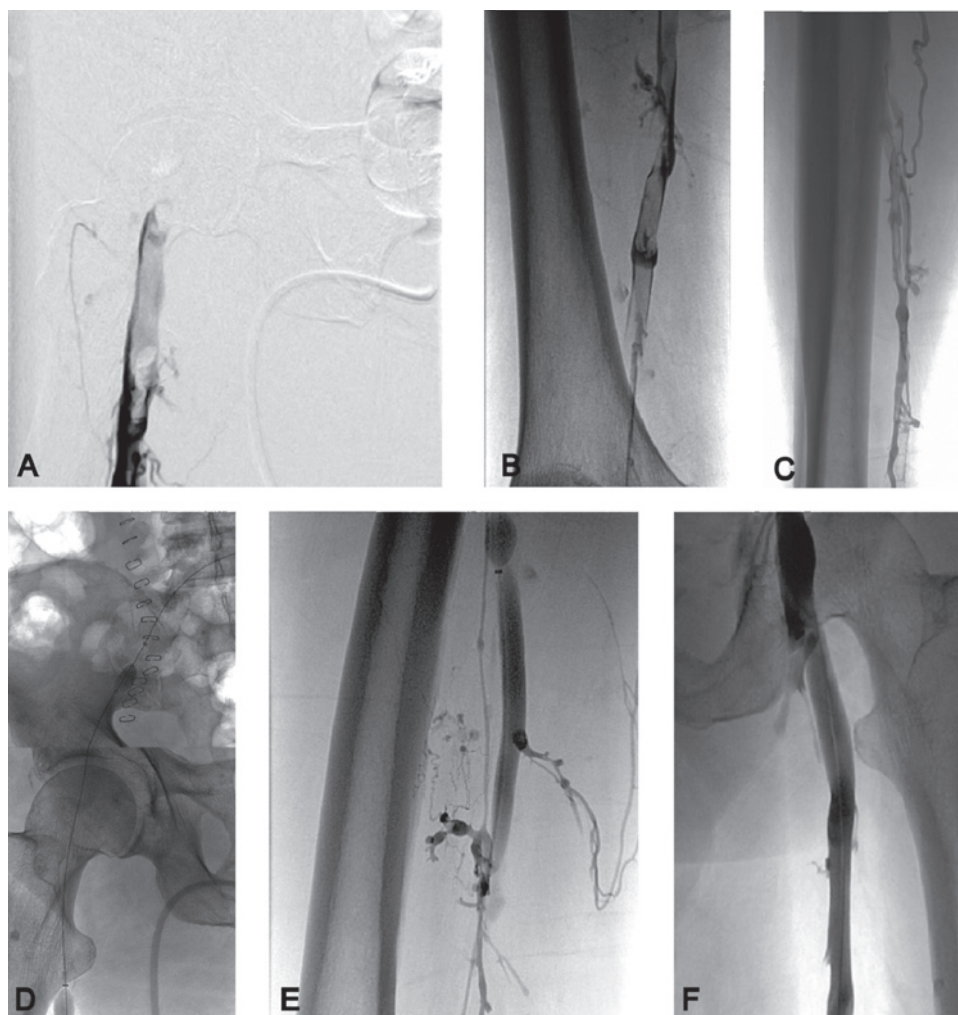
A, B, C. Phlebogram of a patient two days after exploratory laparotomy shows left iliofemoral, femoropopliteal, and posterior tibial DVT. The treatment goal was to lyse the extensive thrombus rapidly with minimal systemic exposure to the plasminogen activator. D. This was accomplished using segmental pharmacomechanical thrombolysis with the hybrid Trellis peripheral infusion system (Bacchus Vascular, Santa Clara, CA) and ultrasound accelerated thrombolysis of popliteal and tibial thrombus with the EKOS LysUS® System (EKOS Corp, Bothell, WA). The Trellis system achieves isolated thrombolysis between two occluding balloons by lytic infusion and mechanical drug dispersion with the intervening catheter rotating at 15,000rpm. This mechanism of thrombolysis enables focused treatment of thrombus within the target vessel. E, F. Phlebogram 30 minutes after using the Trellis system shows resolution of the thrombus in the iliac and femoral veins.
